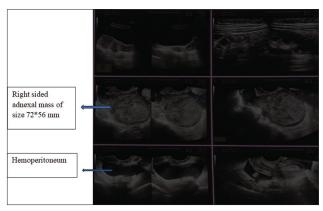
Trans abdominal sonography showing right adnexal mass with hemoperitoneum
